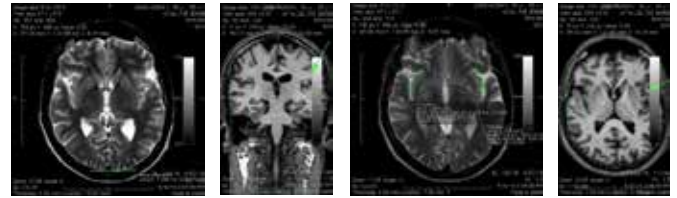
Anatomical brain MRI, from left to right 1) Left occipital petalia (left hemisphere protrudes posteriorly.) 2) Left temporal planum size is bigger than right temporal planum. 3) Left insular cortex length is longer than the right side. 4) Left sylvian fissure is longer than the right side.
